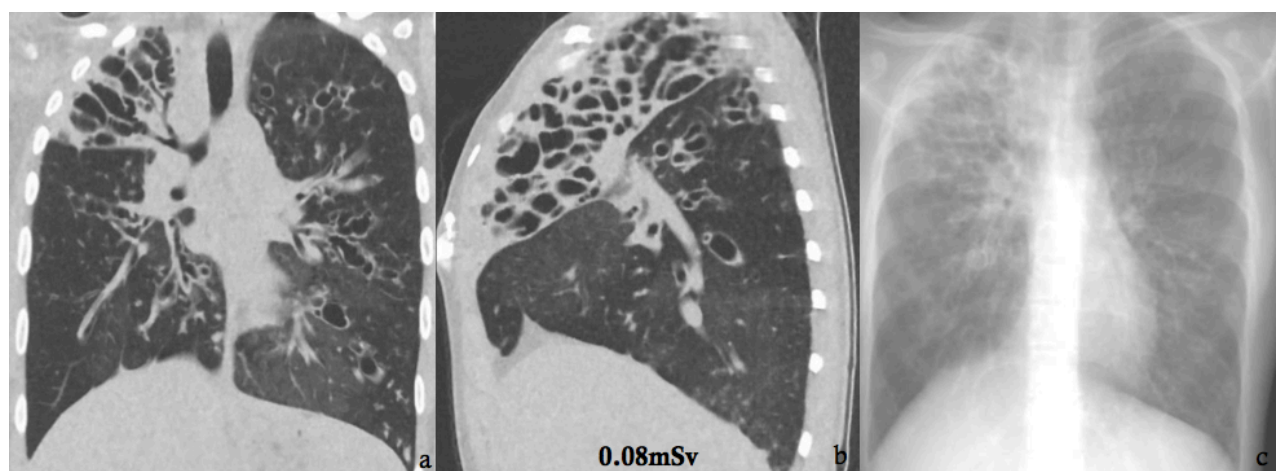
Representative coronal (a) and sagittal (b) CT images with a digital ray sum chest radiograph (e) acquired in 20-year-old male patient with cystic fibrosis at 24 months of treatment with Ivacaftor using the volumetric low-dose MBIR protocol (effective dose 0.08mSv). There is severe bronchiectasis affecting more than nine bronchopulmonary segments and sixth-generation bronchial divisions. Bronchial wall thickening was moderate with mucous plugging affected more than nine bronchopulmonary segments. There were fewer than five sacculations, fewer than three bullae, and no lung consolidation or collapse. The Bhalla score was 16.
